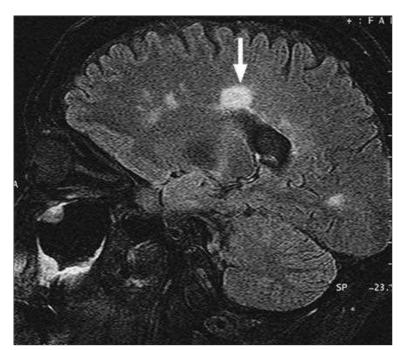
Fluid-Attenuated Inversion Recovery (FLAIR). FLAIR sequences help reveal demyelination in the central nervous system that often is not visible on routine magnetic resonance imaging (*arrow*). (Courtesy Dr. Ramon Figueroa.)
